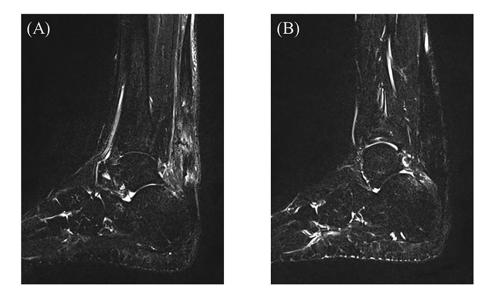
The abnormal intensity at the repaired site of the Achilles tendon at pre-injection of FD-PFC in T2-STIR of MRI (A) improved at 12 weeks after the operation (B).
